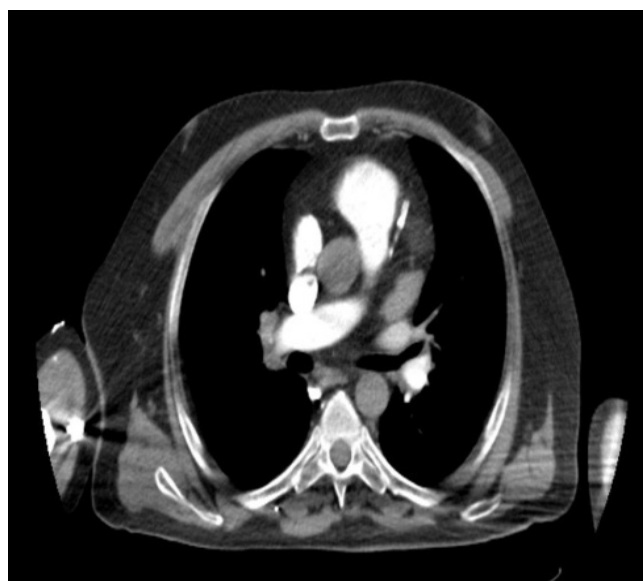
PTE compatible filling defects in the patient's pulmonary CT angiography.
